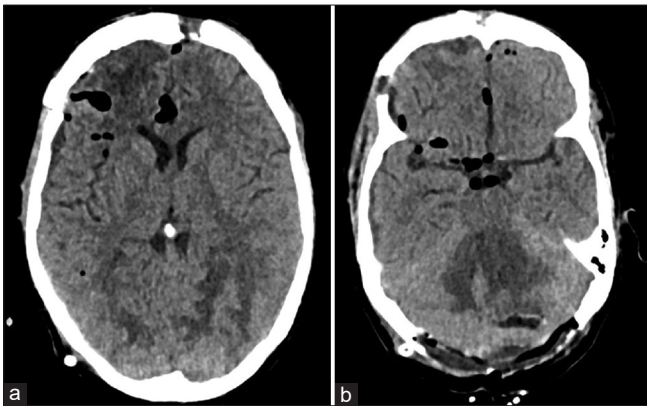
Postoperative computed tomography head – (a and b) (a) axial cuts – showing tumor decompression of the right frontal lesion and (b) tumor decompression of posterior fossa lesion with posterior fossa decompression.
